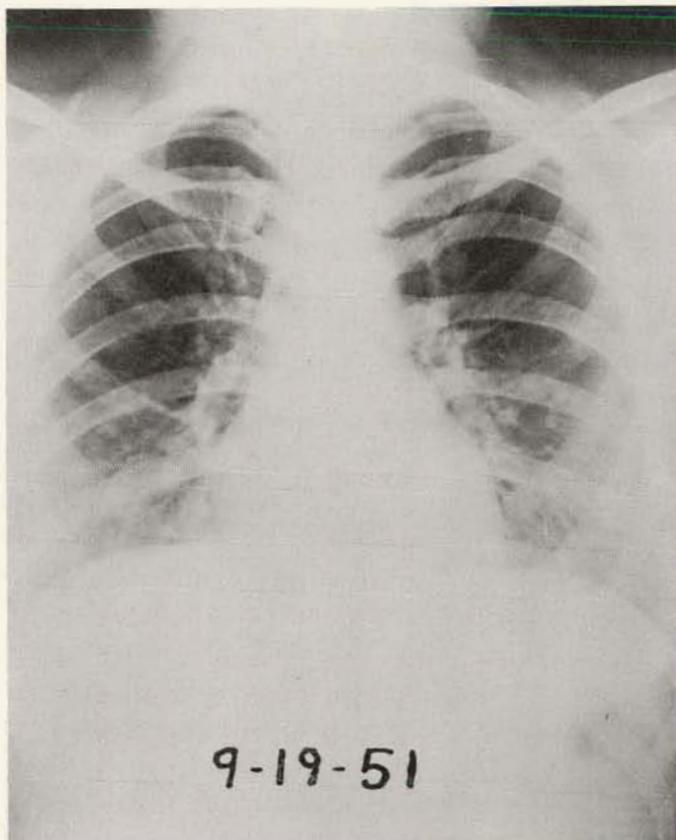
Same patient as shown in Figures 71 to 73. Roentgenograph of chest, September 19, 1951, 10 months after total thyroidectomy. I^{131} uptake was 9.5% in 24 hrs., chiefly in neck. I^{131} treatment, 50 mc. Daily administration of 2 grains of desiccated thyroid had been stopped on August 18, 1951; on October 15, 1951, daily administration of 3 grains was begun.
